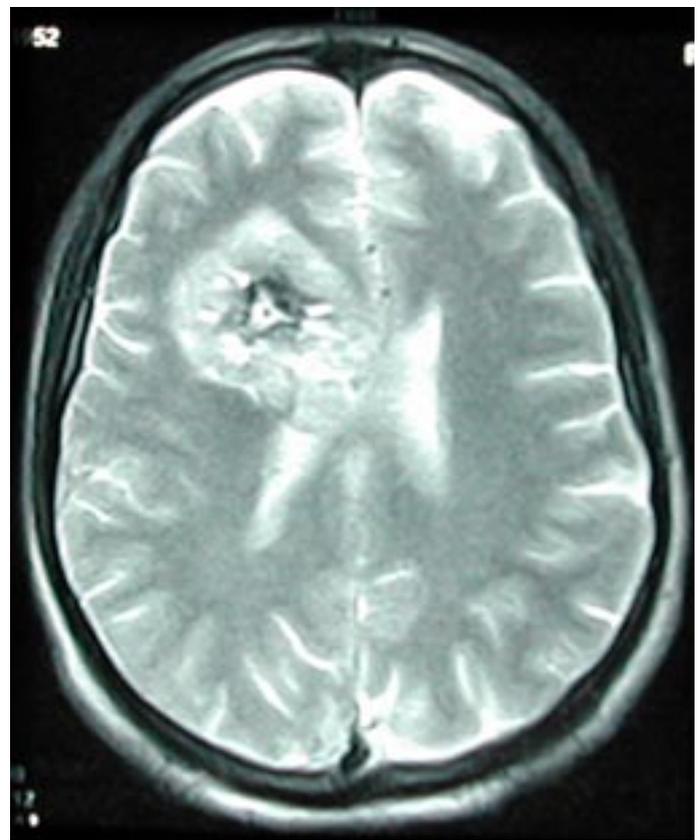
MRI shows high signal intensity on T2-weighted image.
